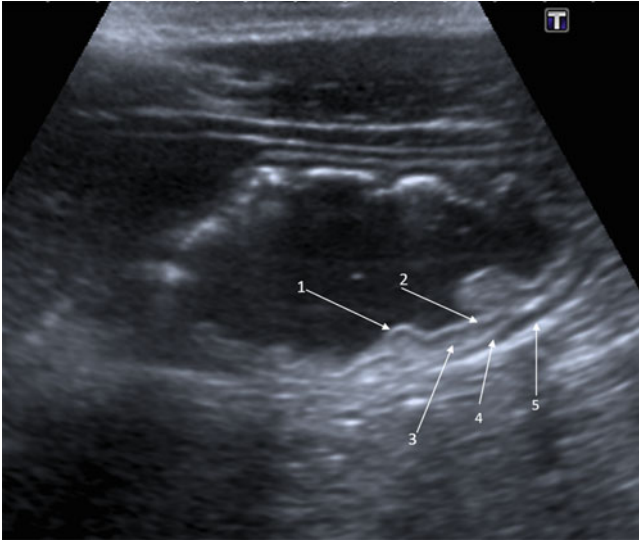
High resolution ultrasound of normal terminal ileum, following oral fluid load, showing the five bowel wall layers outlined in Fig. 13.2. 1. Superficial mucosa; 2. Deep mucosa; 3. Submucosa; 4. Muscularis; 5. Serosa
